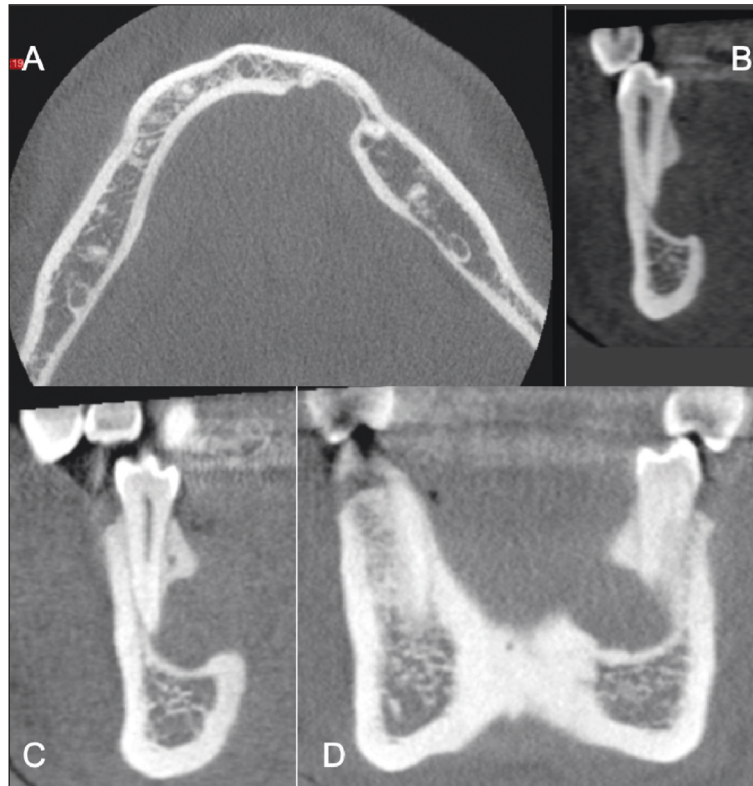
Cone-beam computed tomography images of anterior Stafne bone cavity case located in the left premolar area. A. Axial section view, B. Cross-sectional view, C. Sagittal section view, D. Coronal section view.
